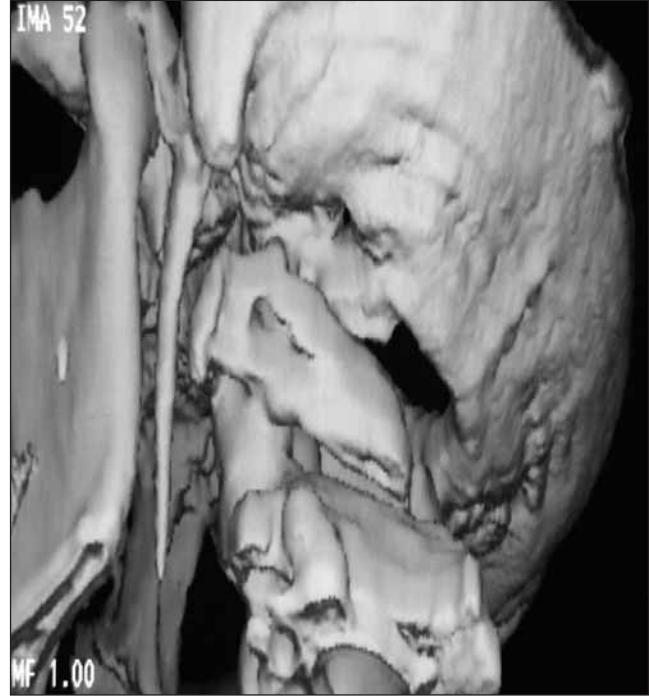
Three-dimensional reconstruction of computed tomography showing left elongated styloid process.
